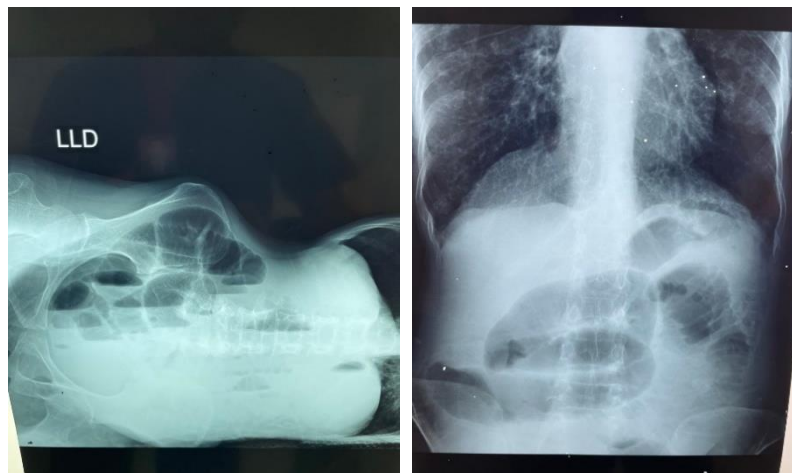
Plain abdominal radiographs show features of intestinal obstruction.
